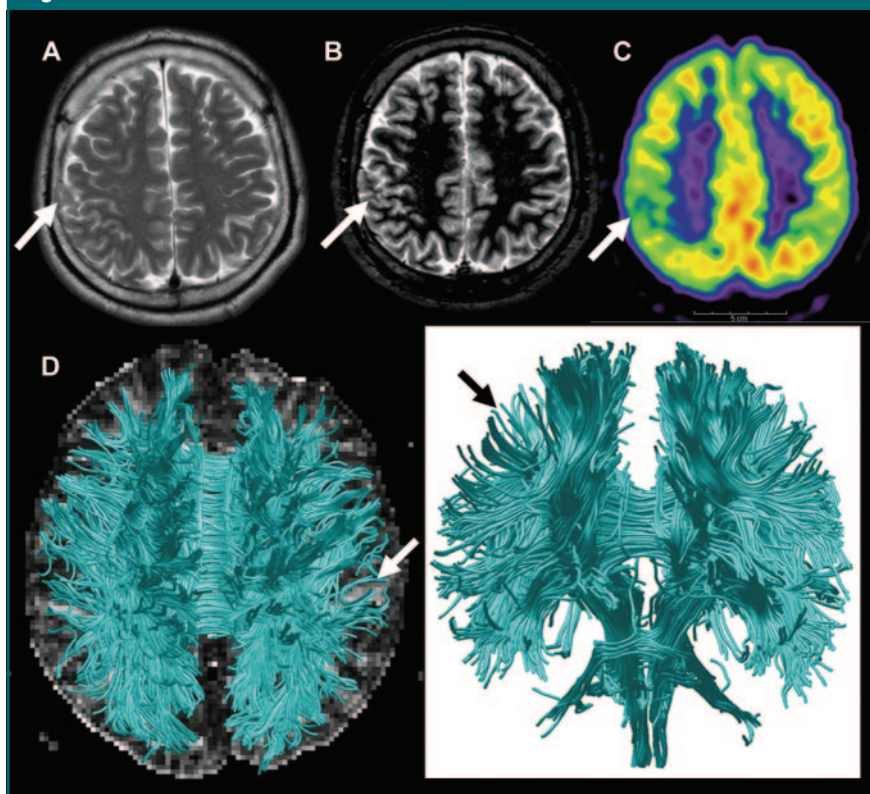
Images in 17-year-old boy with left-side motor seizure. *A*, Equivocal finding (arrow) on transverse T2-weighted image (4000/100; matrix, 352 × 352; FOV, 230 × 230 mm; section thickness, 5 mm). *B*, Transverse fast inversion recovery with myelin suppression image (repetition time msec/echo time msec/inversion time msec, 4500/22/300; section thickness, 3 mm; matrix, 256 × 256; FOV, 230 × 230 mm) shows focal cortical dysplasia in right precentral gyrus (arrow). *C*, Transverse fluorine 18 fluorodeoxyglucose positron emission tomography reveals decreased metabolism in right precentral area. *D*, Whole-brain white matter tractography (blue-green) depicts decreased subcortical fiber connectivity in right precentral area and adjacent cortex (DT imaging: 32 directions; six-channel sensitivity encoding; sensitivity encoding factor of two; *b* value, 600 sec/mm²; 6599–8280/70; matrix, 96 × 96; FOV, 220 × 220 mm; section thickness, 2.3 mm).
